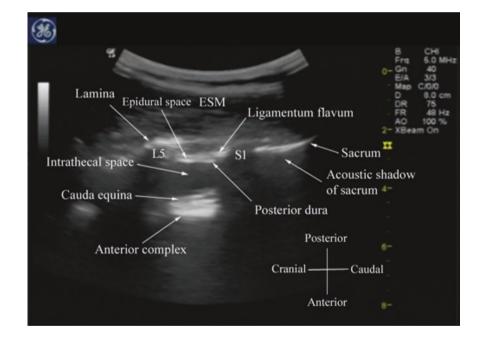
Paramedian sagittal sonogram of the lumbosacral junction. The posterior surface of the sacrum is identified as a flat hyperechoic surface with a large acoustic shadow anterior to it. The dip or gap between the sacrum and the lamina of L5 is the L5/S1 intervertebral space. ESM erector spinae muscle. (Reproduced with permission from www.aic. cuhk.edu.hk/usgraweb)
